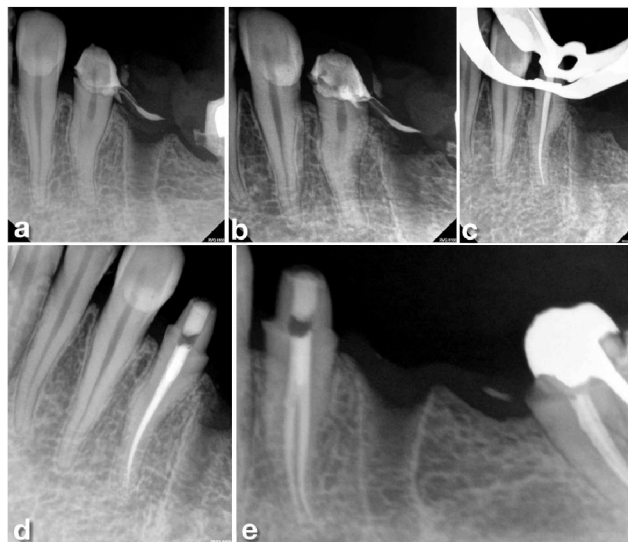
Case1: a,b, preoperative radiograph (straight and mesial shift). c, master cone radiograph. d,e, Postoperative radiograph (straight and mesial shift).
